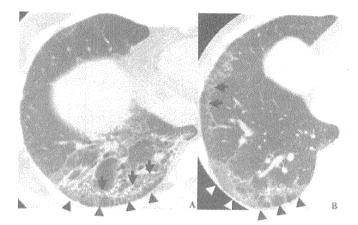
HRCT images showing lower reticulation pattern. A: A 47-year-old woman negative for anti-CADM-140 (PL-7-positive). Peripheral intralobular reticular opacities with subpleural sparing were the dominant finding (arrowheads). GGAs, interlobular septal thickening, non-septal linear or plate-like opacities, and traction bronchiectasis (arrows) were also observed. The patient remained alive 6 years after diagnosis. B: A 52-year-old woman negative for anti-CADM-140 (Jo-1-positive). Peripheral intralobular reticular opacities with subpleural sparing were the dominant findings (arrowheads). Interlobular septal thickening and non-septal linear or plate-like opacities were also prominent (arrows). The patient remained alive 6 years after diagnosis.
